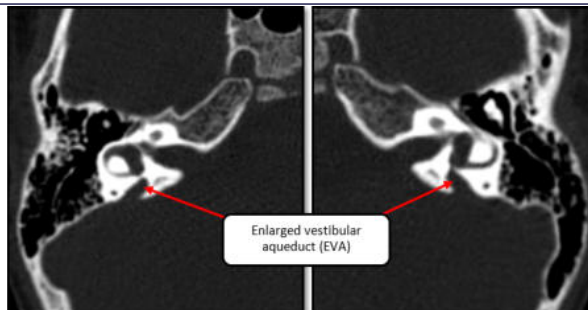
HRCT scan of temporal bones of child showing bilateral Enlarged Vestibular Aqueduct (EVA)
